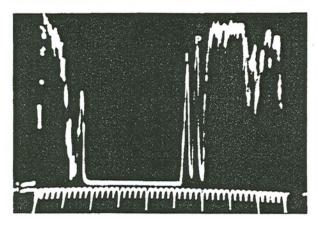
B-scan ultrasonography of posterior vitreoschisis. Splitting of the posterior vitreous cortex (white arrow) can mimic posterior vitreous detachment. The tissue that remains attached to the macula (P) can induce macular pucker or macular holes (I = inner wall of vitreoschisis cavity; P = outer wall). Reprinted with permission from: Green RL, Byrne SF. Clinical ultrasonography. In: Ryan SJ, ed. Retina. St. Louis: Mosby, 1989.
